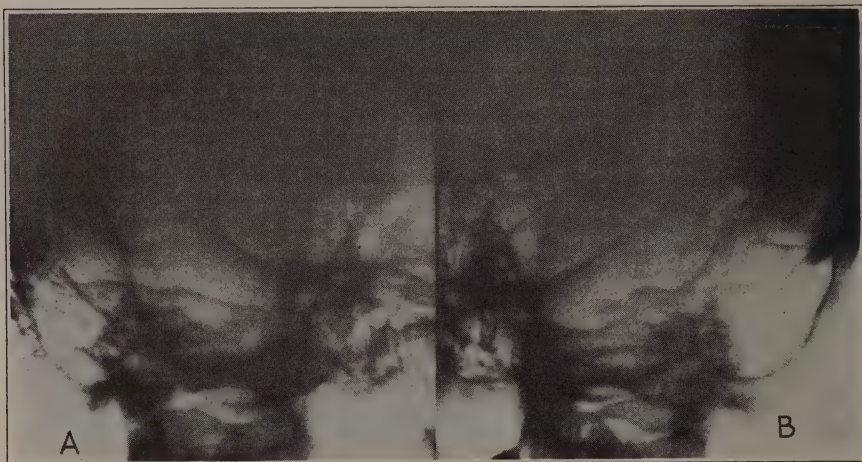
(*Case 2*). Roentgenogram showing clouding of the area of the apex tip and the perilabyrinthine area of the left side as compared with the normal structures of the other side. Note the loss of definition of the roof of the apex cell.
